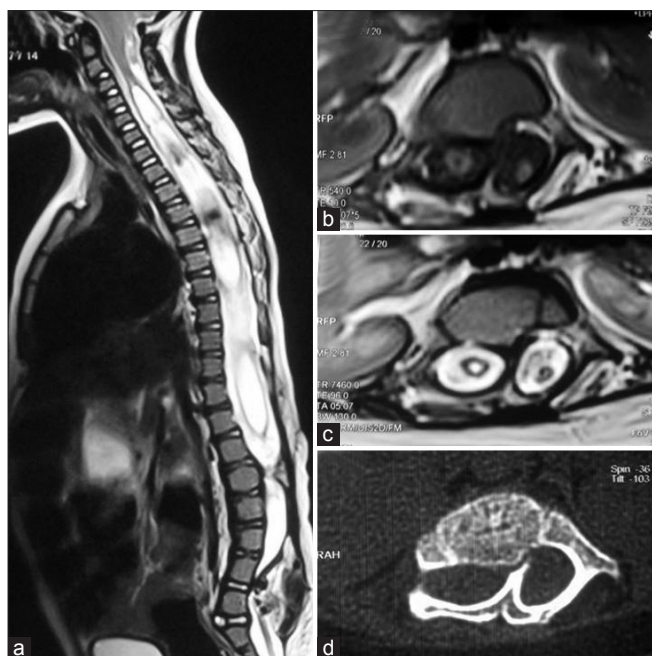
(a-d) Sagittal, axial T1W, axial T2W MRI images and axial CT image of a representative case showing SCM type I with dorsally located bony spur at D12 vertebral level. Also note low lying cord and long segment syrinx
